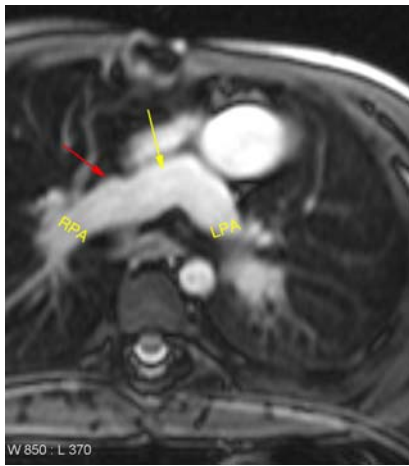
MRI of the left (LPA) and right pulmonary artery (RPA) at the superior vena cava (SVC) anastomosis site (yellow arrow). The flared initial baffle anastomosis region is shown with a red arrow.
